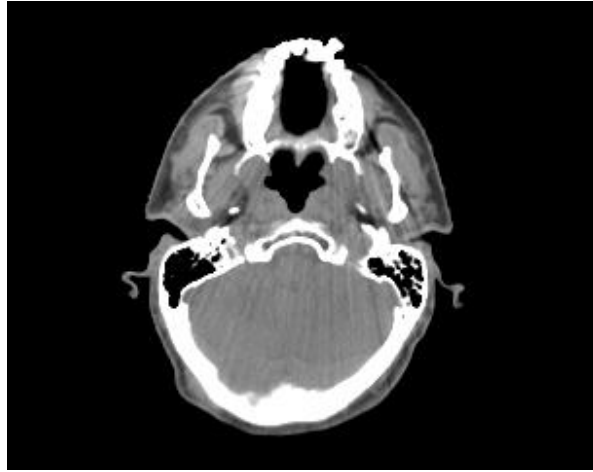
Axial CT image of the neck was used for comparison. [33]
